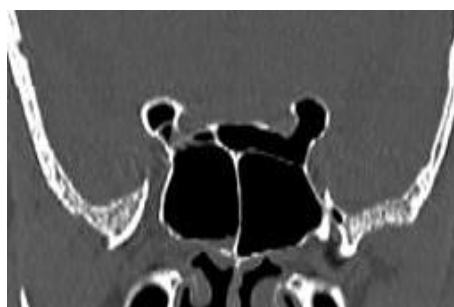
Coronal CT scan showing Onodi cell and type 4 optic nerve on both sides. Inter Onodi septa is attaching to right optic canal. ACP is showing pneumatization from Onodi cells on both sides.
